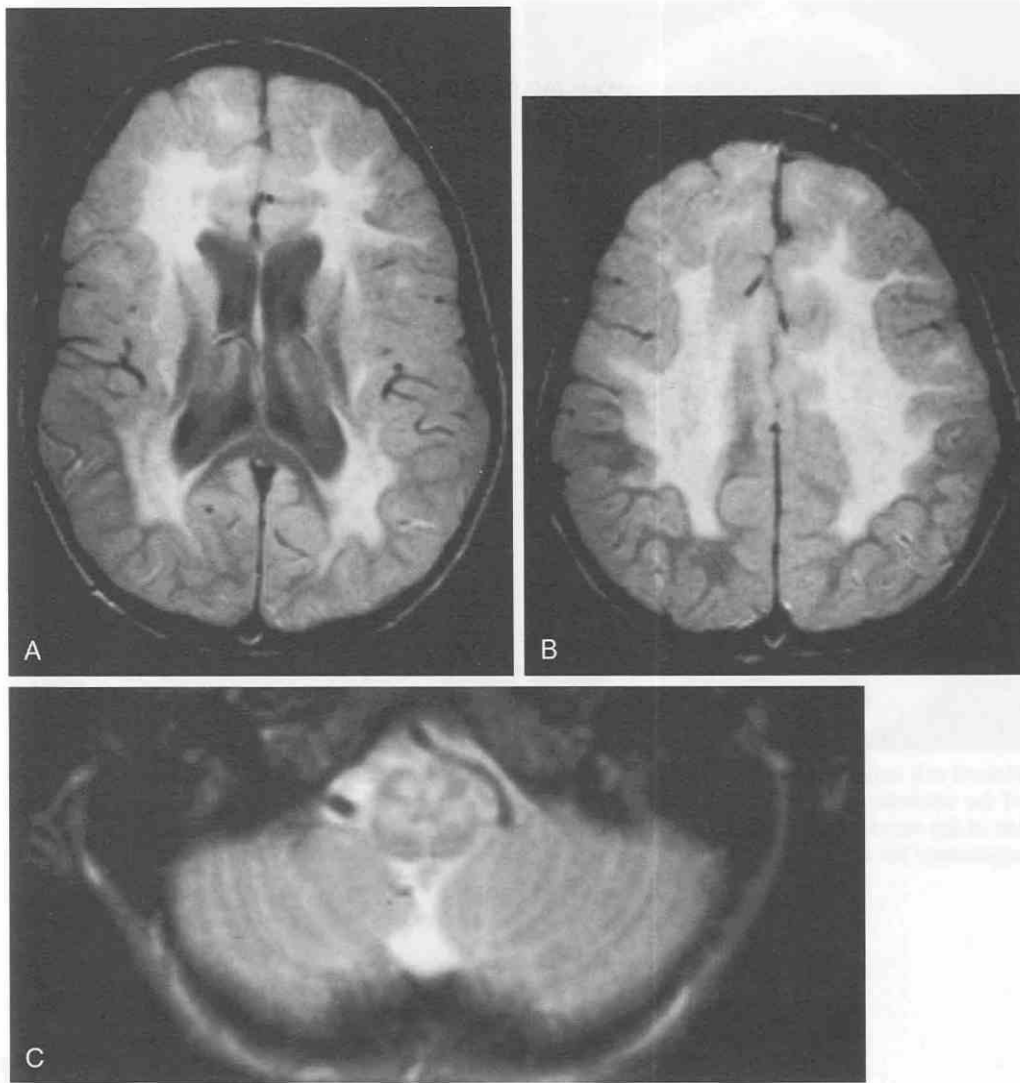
Metachromatic leukodystrophy (MLD) in a 6-year-old boy. A and B, Cranial MR axial proton-density images show severe demyelination involving the deep white matter of both hemispheres with well-defined borders at the subcortical U-fiber junction. The corpus callosum and internal capsules retain some normal hypointense myelin signal. C, Axial T2-weighted MR image at the level of the medulla depicts significant demyelination.
